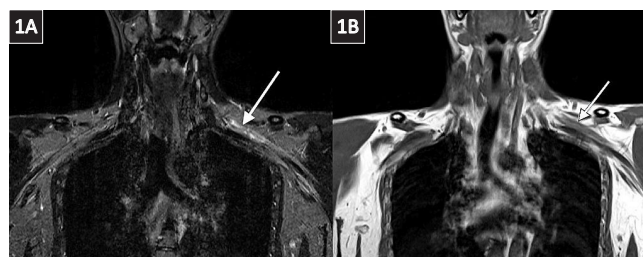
(A) Magnetic resonance imaging (MRI) of brachial plexus coronal short tau inversion recovery (STIR) sequence shows mildly increased signal along the course of the distal trunks and divisions of the left brachial plexus (white arrow). (B) MRI of coronal T1 sequence shows partial effacement of intervening fat planes between the nerves (white arrow), indicating inflammation in all trunks, divisions and cords of the brachial plexus.
